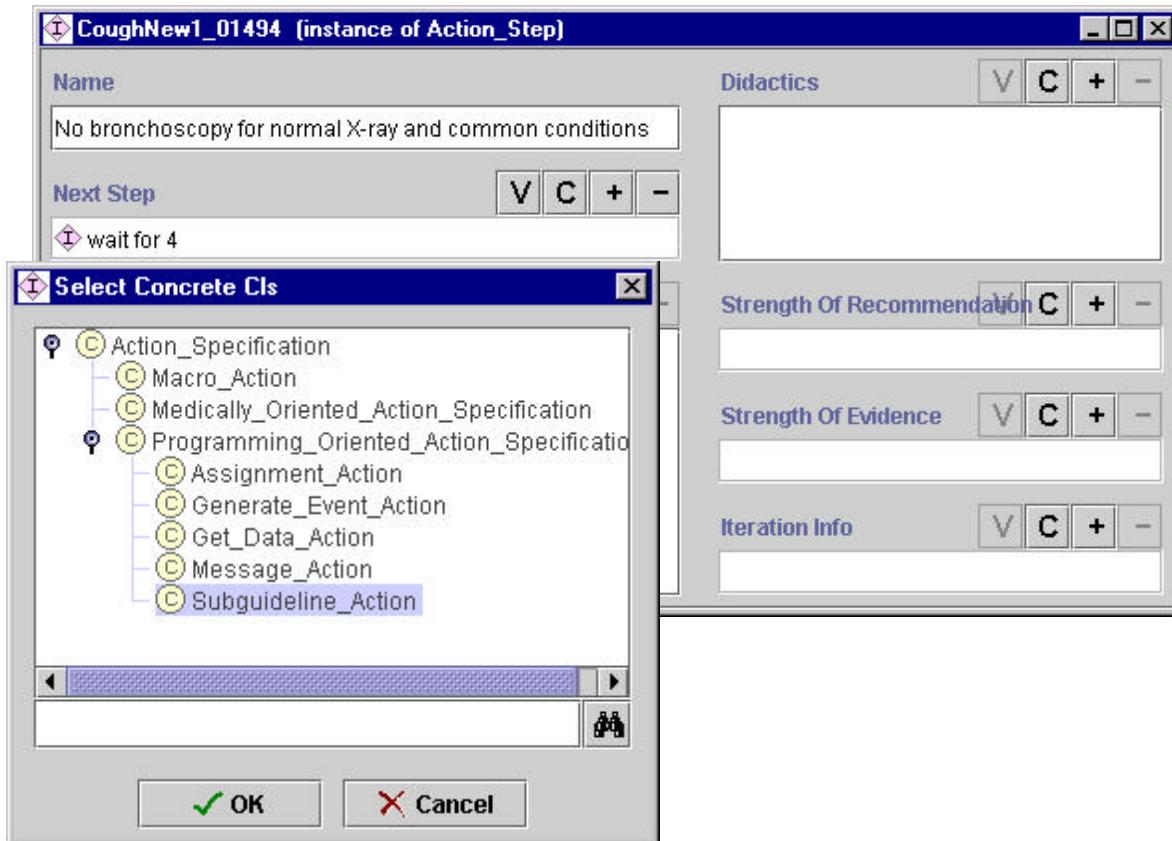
Details of the action step “No bronchoscopy for normal X-ray” action step, shown in Figure 3.
